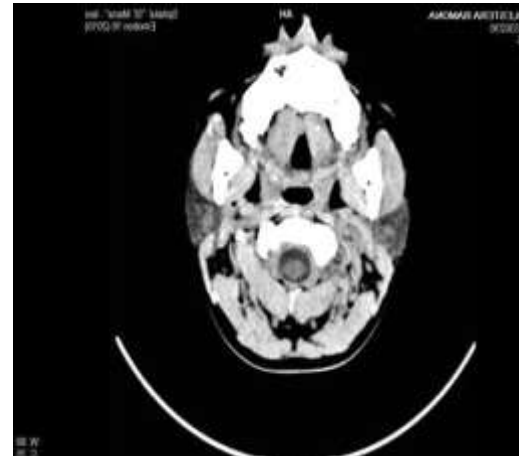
Patient 2 – Brown tumour of hard palate/CT
